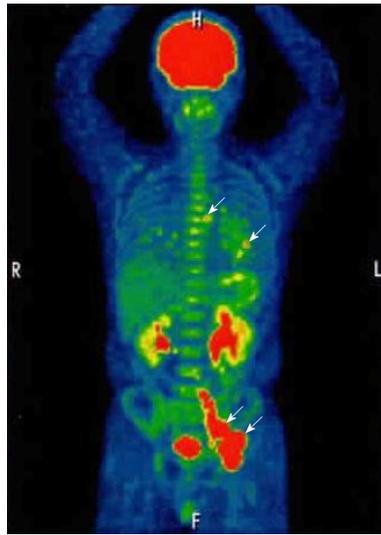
Positron emission tomography/computed tomography (longitudinal) image. Arrows indicate lymphoma lesions. The mean of the standardized uptake value was 18.1 in the multiple lymph node lesions continuing to the mesentery and para-aortic/left common iliac artery/left inguinal, 3.5 in the lesions of the lung fields and the mediastinal nodes. No uptake in the stomach and duodenum.
